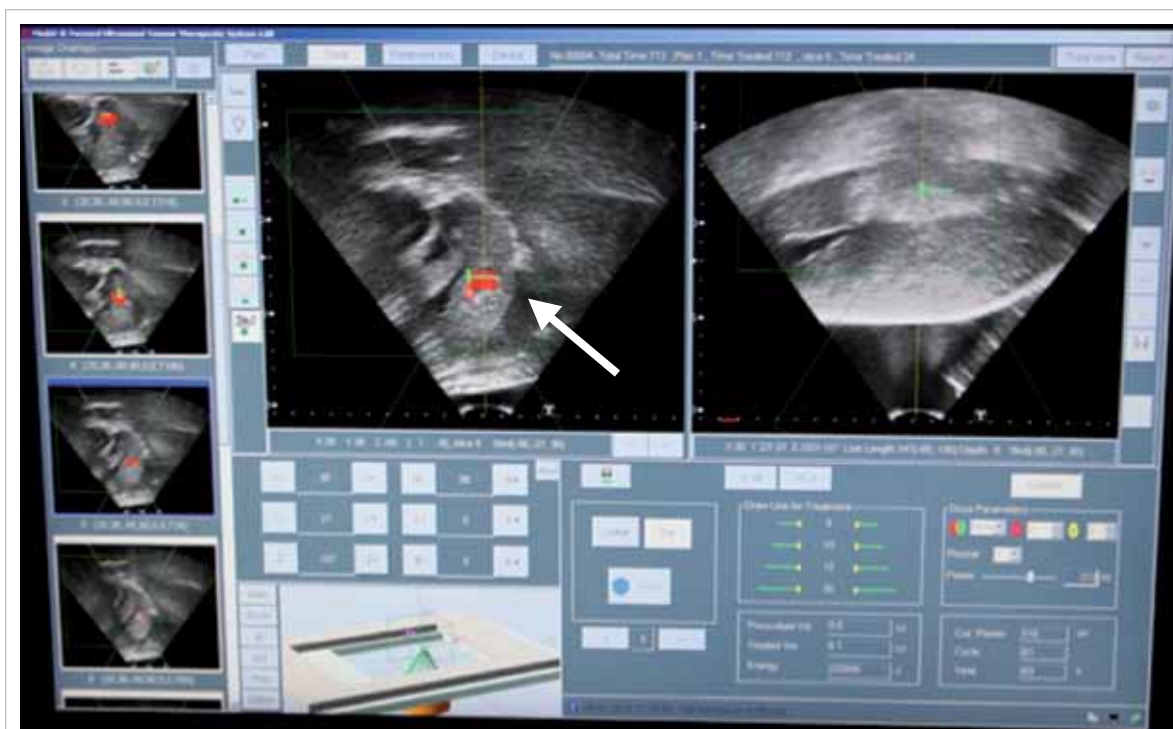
The lesion (arrow) is identified and fired by high-intensity focused ultrasound
